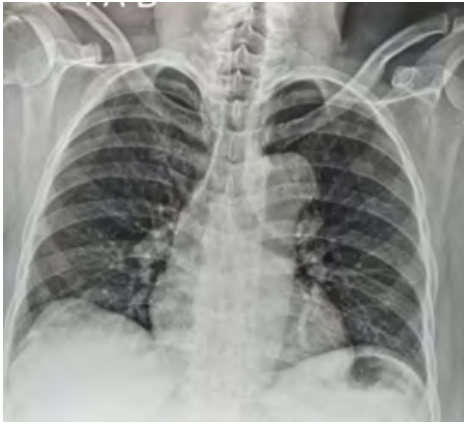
Radiographie du thorax de face Déroulement du bouton aortique
